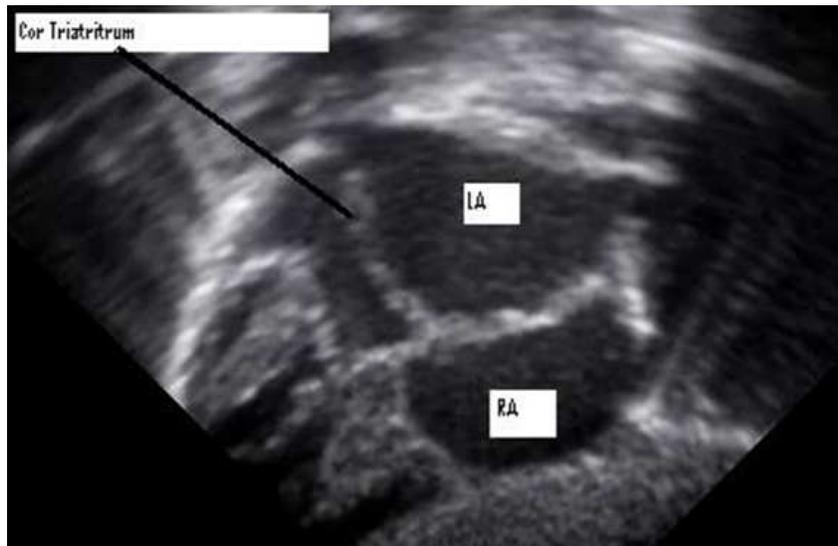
Long axis of parasternal view shows the fibromuscular membrane in left atrium.
